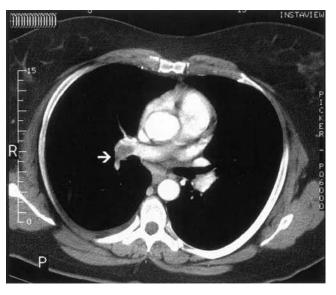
Axial image of the chest from a four-channel multidetector spiral computed tomographic scan performed after administration of intravenous contrast. There is enhancement of the pulmonary artery with a large thrombus on the right (*arrow*) consistent with pulmonary embolism. (Reproduced with permission from Dr. Michael Landay.)
